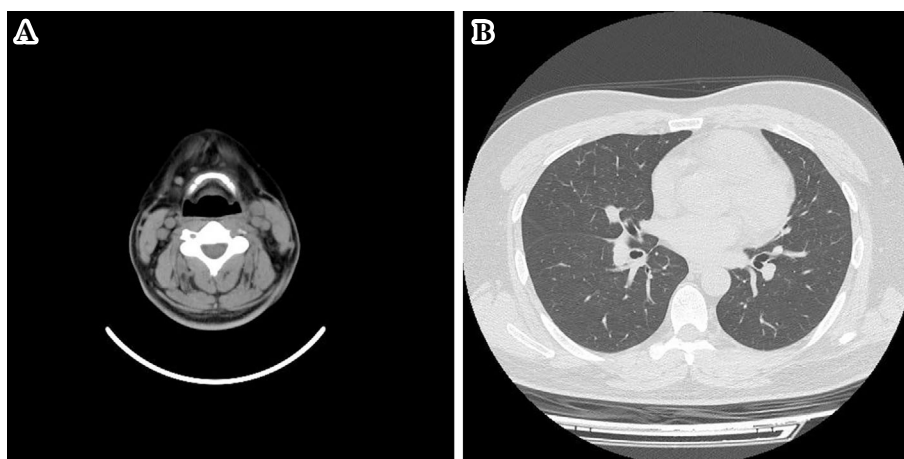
On the third day after admission, computed tomography (CT) revealed an enlargement of multiple cervical lymph nodes (A) but no abnormalities in the lungs (B).
